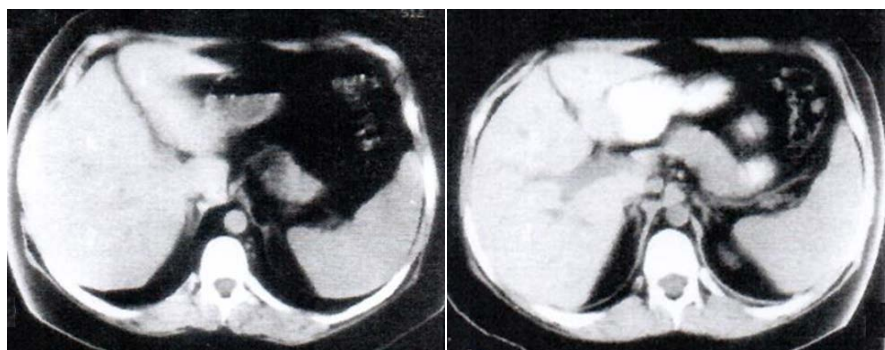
CT scan of the liver in a renal patient with iron overload, showing a decrease in hepatic CT density from 86 HU at the start (A) to 75 HU after repeated phlebotomy (B).
